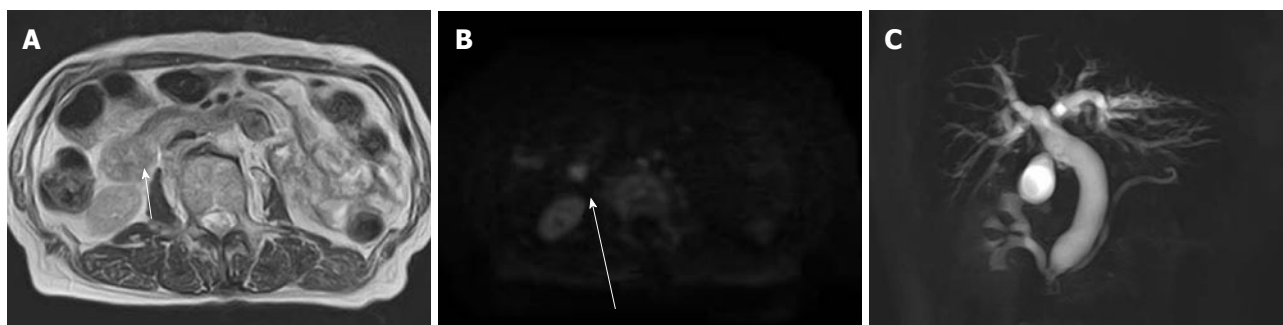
Ampullary cancer in an 84-year-old woman. A: T2-weighted axial image shows a focal mass in the ampullary region (arrow); B: Diffusion-weighted imaging shows high signal intensity within an ampullary cancer (arrow); C: Magnetic resonance cholangiopancreatography shows marked dilatation of the bile duct and slight dilatation of the main pancreatic duct.
